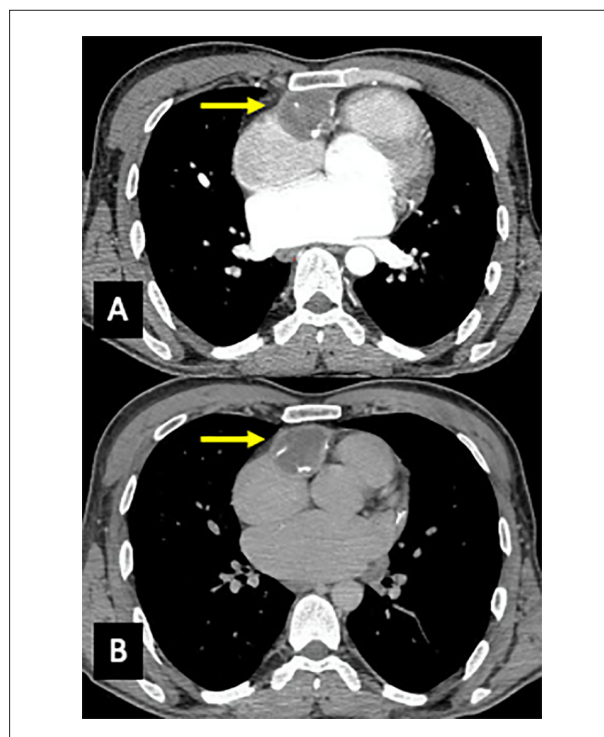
Chest computed tomography. Panels with (A) and without (B) contrast showing collection (yellow arrows) adjacent to the heart's right chambers associated with mild pericardial and mass calcification.
